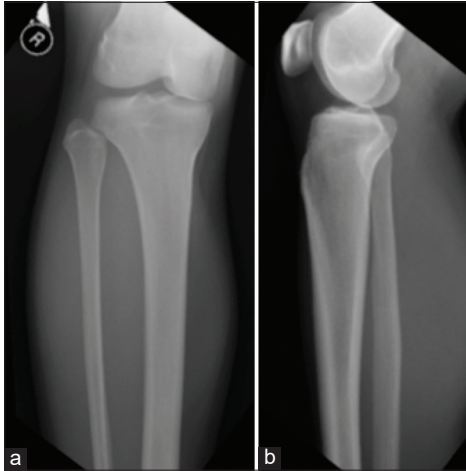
AP and lateral radiograph of knee does not show any calcification in the pretibial region.
